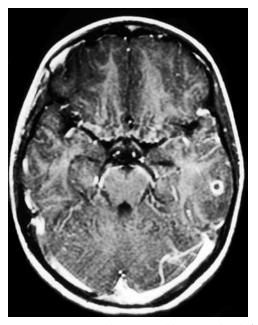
Neurocysticercosis. This 12-year-old presented with focal seizures and chronic headaches after recent travel to an endemic area. MRI revealed a small ring-enhancing cyst in the left temporal lobe with surrounding edema, thought to be consistent with neurocysticercosis. (*Courtesy Patricia Crumrine, MD, Children's Hospital of Pittsburgh, Pittsburgh, Pa.*)
